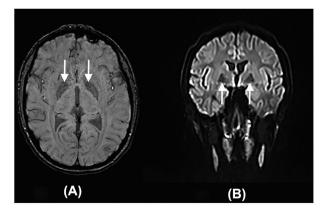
Axial SWI (Panel A) and coronal DWI (Panel B) images of patient BG's brain on admission at the level of the basal ganglia, showing symmetric slight signal dropout in the region of the globus pallidus. Note: This was initially read as indicative of iron deposition in these regions by neuro-radiology, though further review suggested possible infection.
